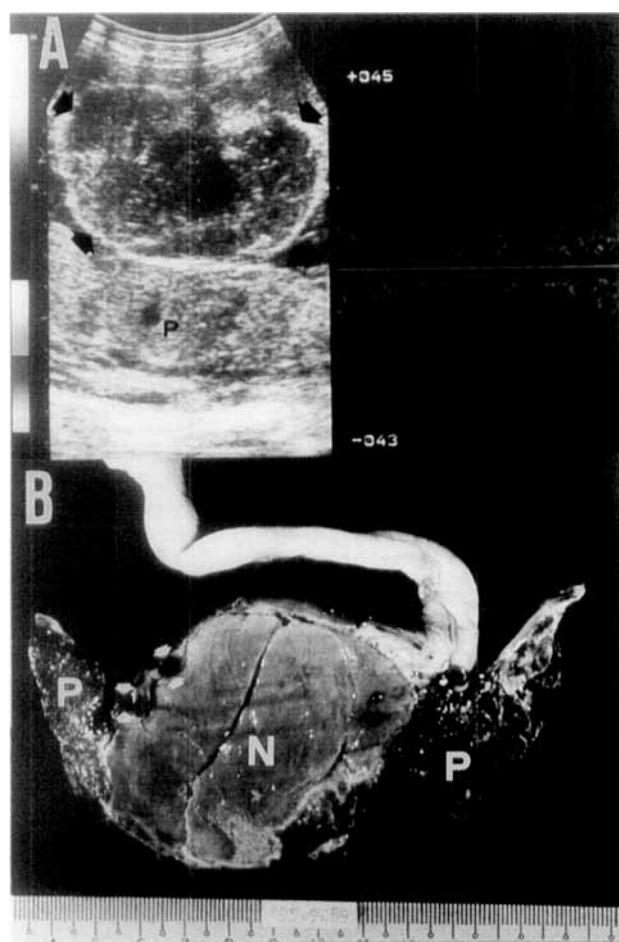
A. Ultrasonic appearance of the chorioangioma (arrows), no flow demonstrated when color flow mapping superimposed. B. Section showing necrosis over a large area, no arteriovenous shunt in the mass, and chorionic vessels (arrows) that cross over the surface. P. normal part of the placenta. N. necrosis.
